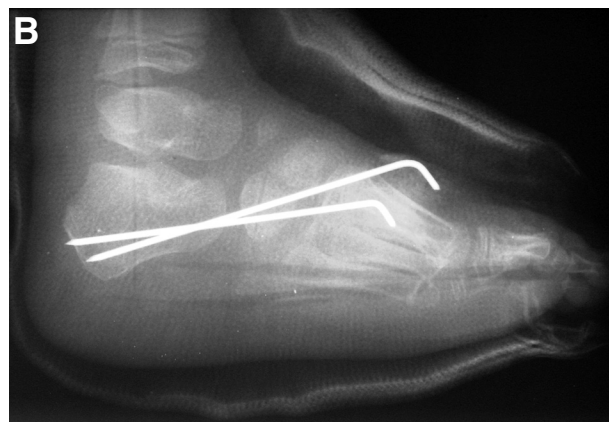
Clinical (A) and radiographic (B) views of the osteotomy of the cuboid-cuneiform.
